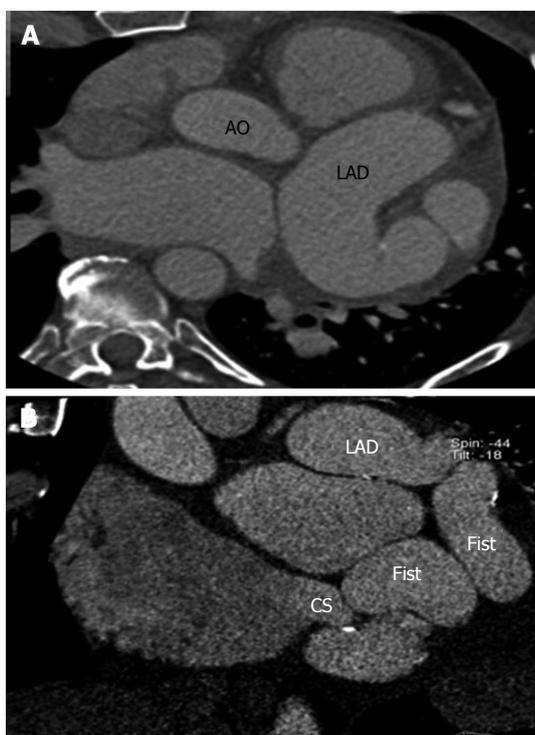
Left anterior descending to coronary sinus fistula. A: Axial coronary computed tomography angiography (CTA) shows dilated, tortuous left anterior descending coronary artery (LAD); B: Sagittal reconstructed coronary CTA shows a LAD fistula draining into the coronary sinus. Fist: Fistula; CS: Coronary sinus; AO: Aorta.
